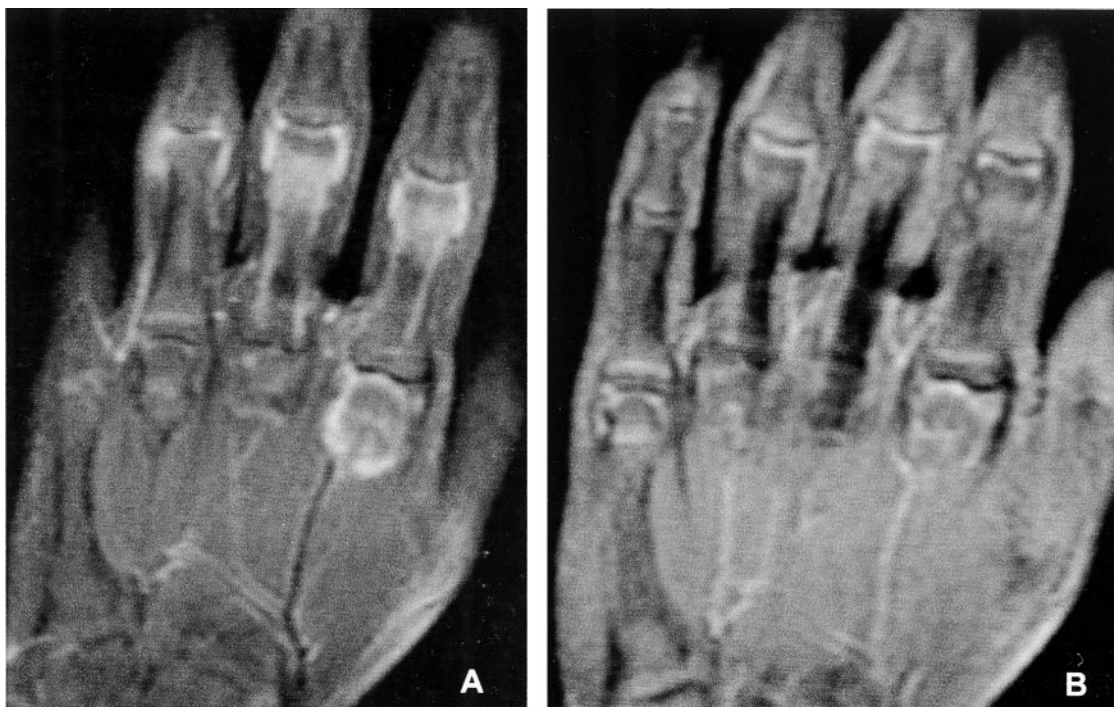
Coronal fat suppressed T1-weighted images (400/14 TR/TE, 4/1 slice thickness mm/gap thickness mm, 256 × 160 matrix, 18 cm FOV) following intravenous contrast administration of the hand of a 12-year-old girl (Patient 6) at study onset (A) and 3 months later (B). There has been a decrease in the amount of enhancing synovium of the first metacarpal-phalangeal and interphalangeal joints over time.
